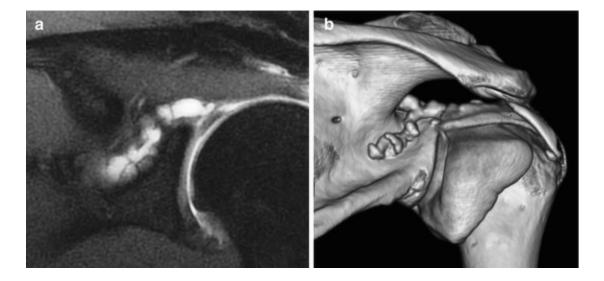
Spinoglenoidal cyst associated with a SLAP lesion. Its long and tortuous path is in agreement with Spinner's theory [12]. (a) Coronal fat-suppressed T1-weighted MR arthrography image with fat suppression shows multiseptated associated with the SLAP lesion. (b) Volume rendering CT arthrography image confirms the MRI findings. (From Blum et al. [25])
